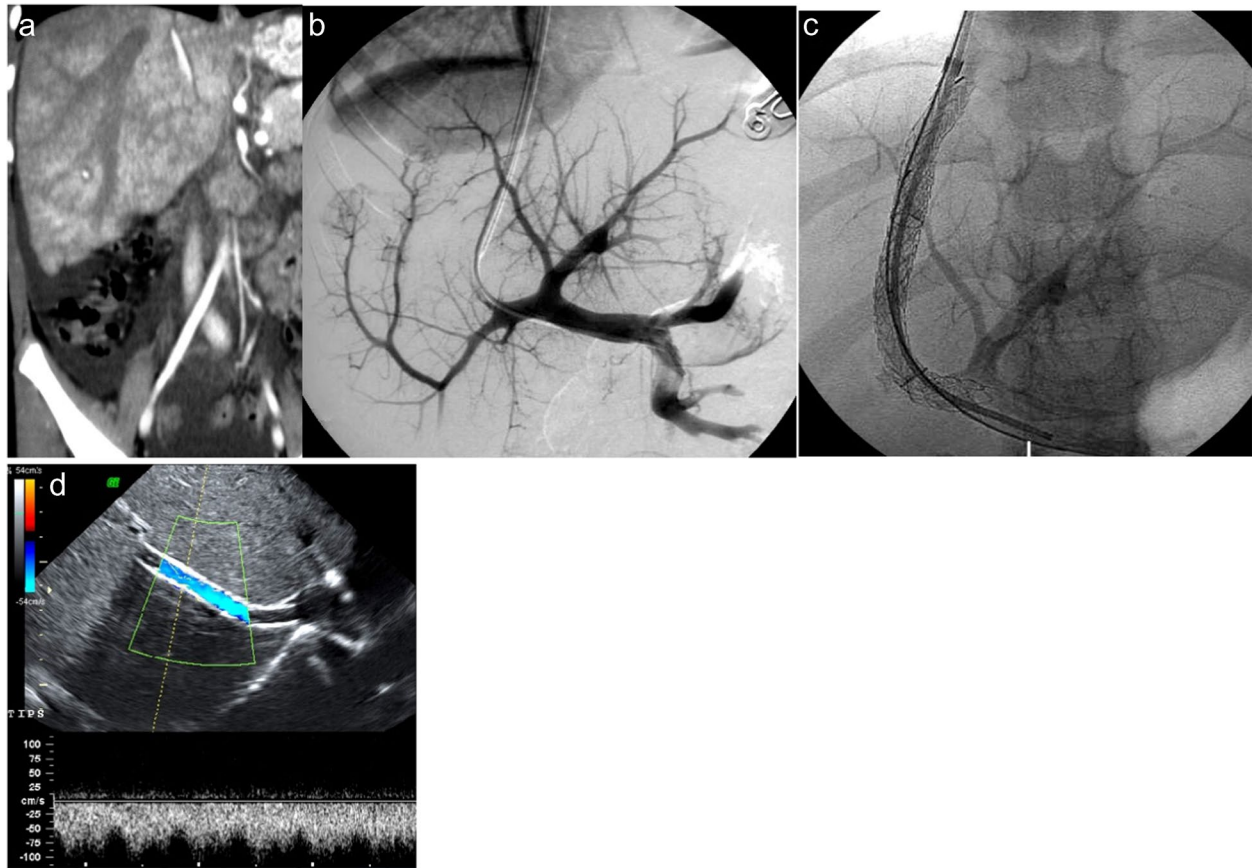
Budd–Chiari syndrome in a 7-year-old girl presenting with refractory ascites secondary to portal hypertension. a Coronal-reformatted maximum intensity projection contrast-enhanced CT in the portal venous phase shows heterogeneous hepatomegaly with absence of enhancement of the enlarged right hepatic vein and partial enhancement with distal narrowing of the middle hepatic vein. After unsuccessful thrombectomy and angioplasty of the hepatic veins, a transjugular intrahepatic portosystemic shunt (TIPS) was created. b Antero-posterior view of the portal venography, following puncture
